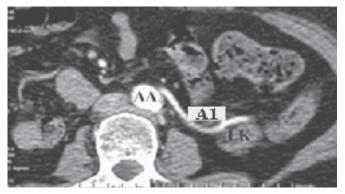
Axial CT scans showed that the first renal artery to the ectopic kidney was from the distal aorta (a), the second renal artery to the ectopic kidney was from the right proximal iliac artery (b), and the location of hilar structures (c). Note the first renal artery courses on the lateral side of the ectopic kidney (b).
